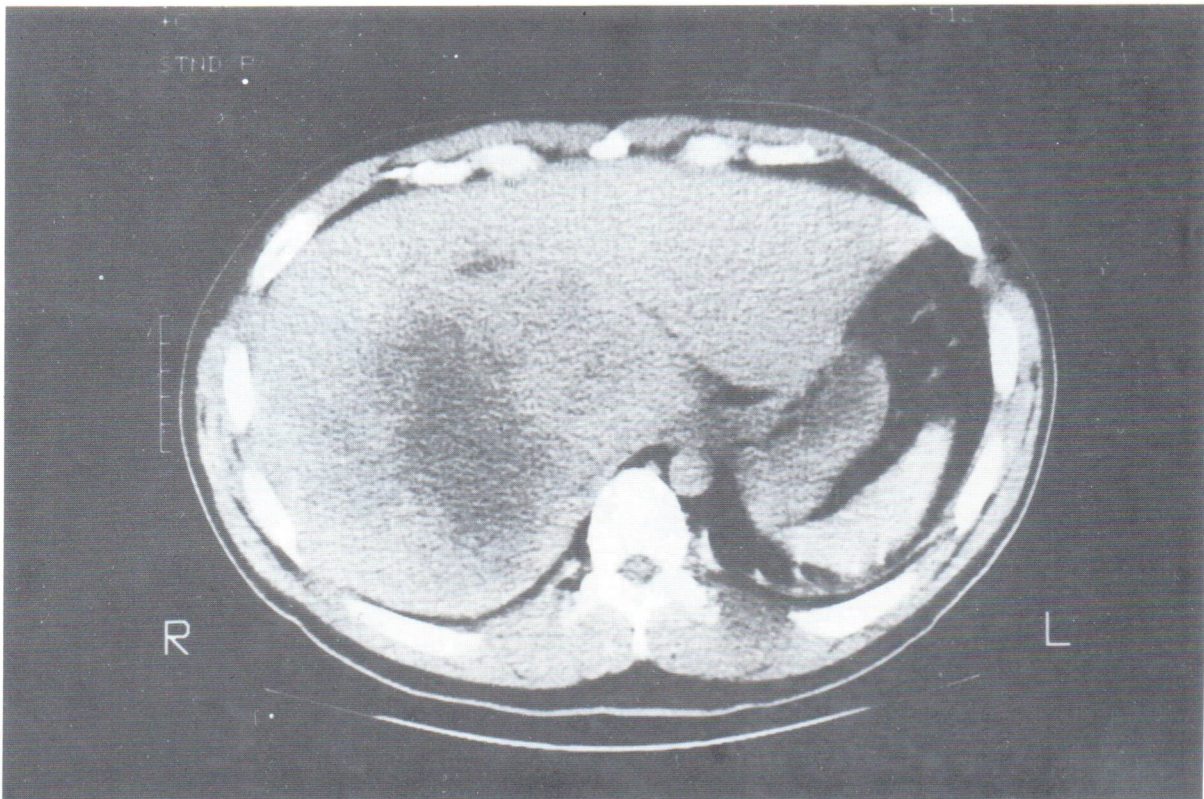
Non-contrast CT scan of the liver showing a poorly defined, predominantly hypodense mass in mainly the right lobe and medial segment of the left lobe.
